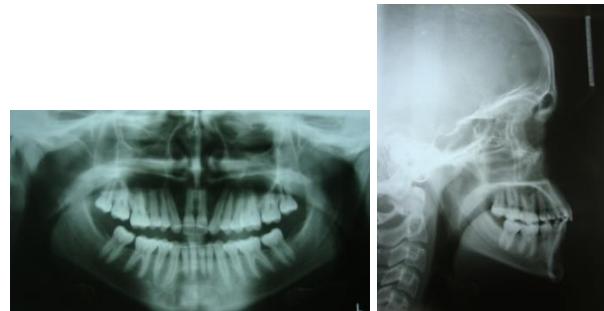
Pretreatment radiographs (a) Panoramic (b) Lateral Cephalogram
